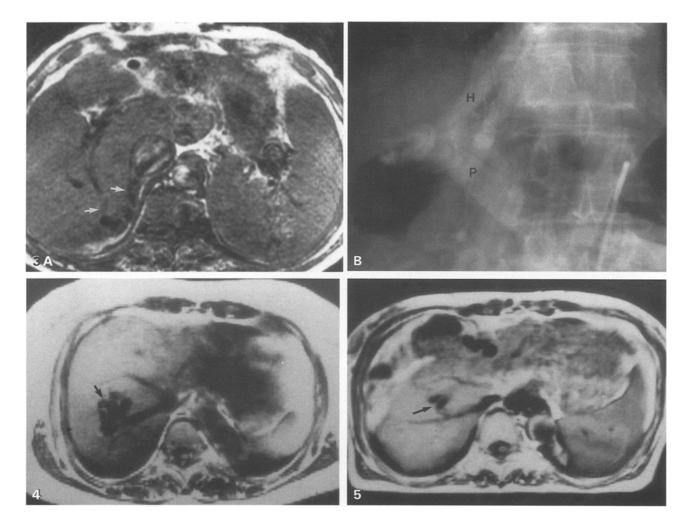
Case 3. A MRI (TR 2500 ms, TE 30 ms) shows a tubular IPHVS (arrows). B Portal phase of celiac arteriography also reveals the IPHVS (arrows).
